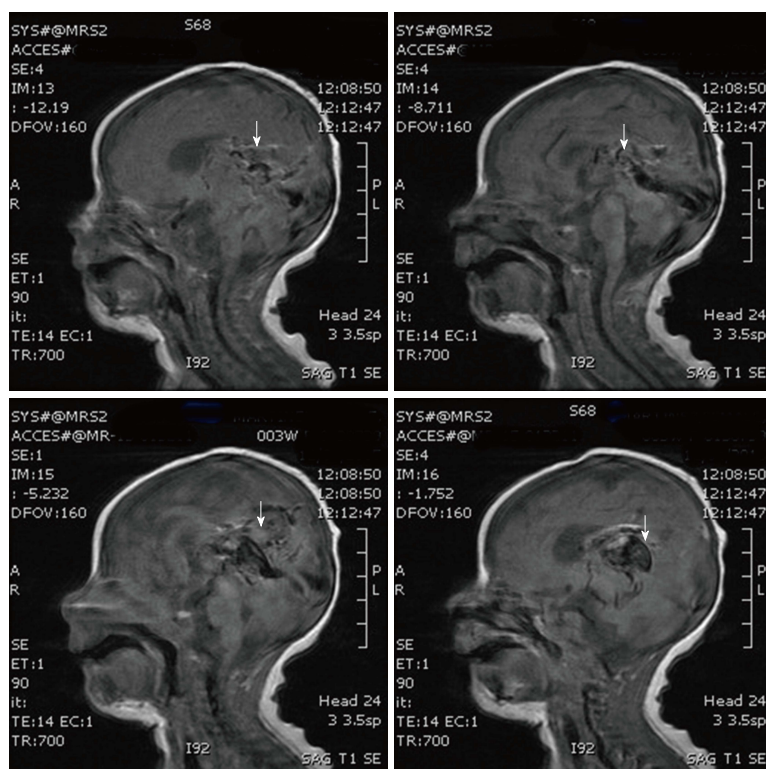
T1-weighted sagittal magnetic resonance images at 41 d of age after 5 embolizations show thrombosis and shrinkage of the median vein of procencephalon and embryonic falcine sinus (arrows).
